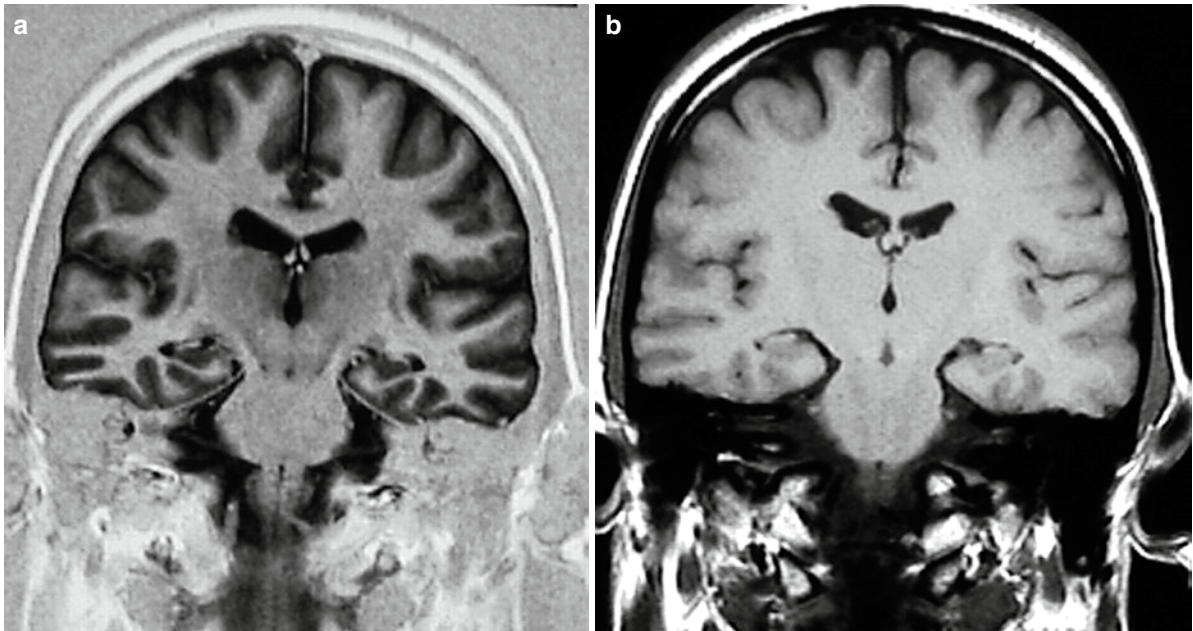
The contrast between gray and white matter is significantly improved on the coronal inversion recovery image (a) compared to the conventional T1-weighted spin-echo image (b)
